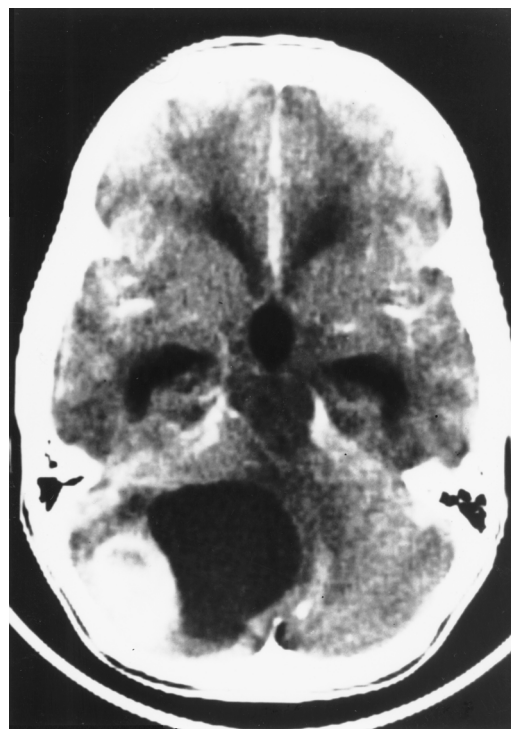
Axial enhanced CT scan of child with cystic cerebellar astrocytoma. Note the enhancement of nodule and not of cyst wall.
